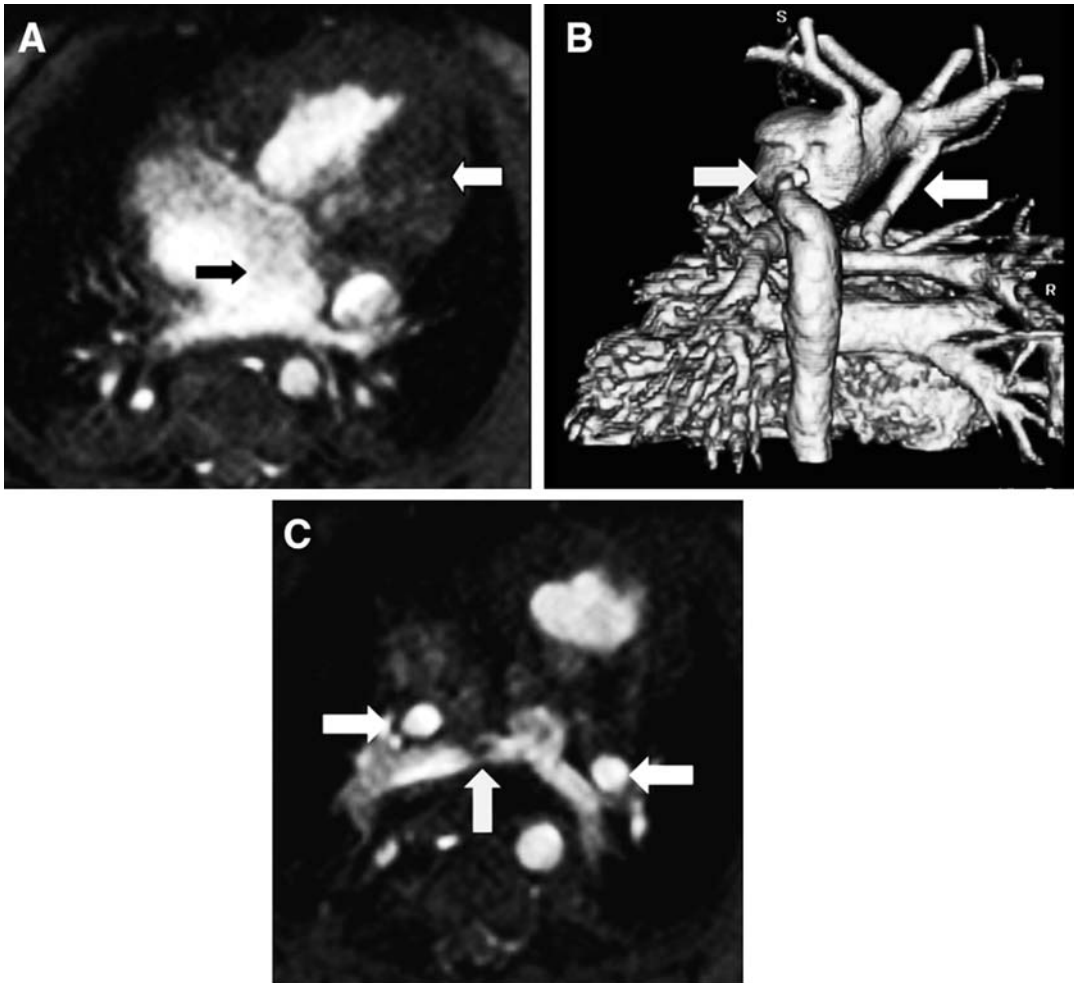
shows MRI for evaluation of repaired tetralogy of Fallot.
